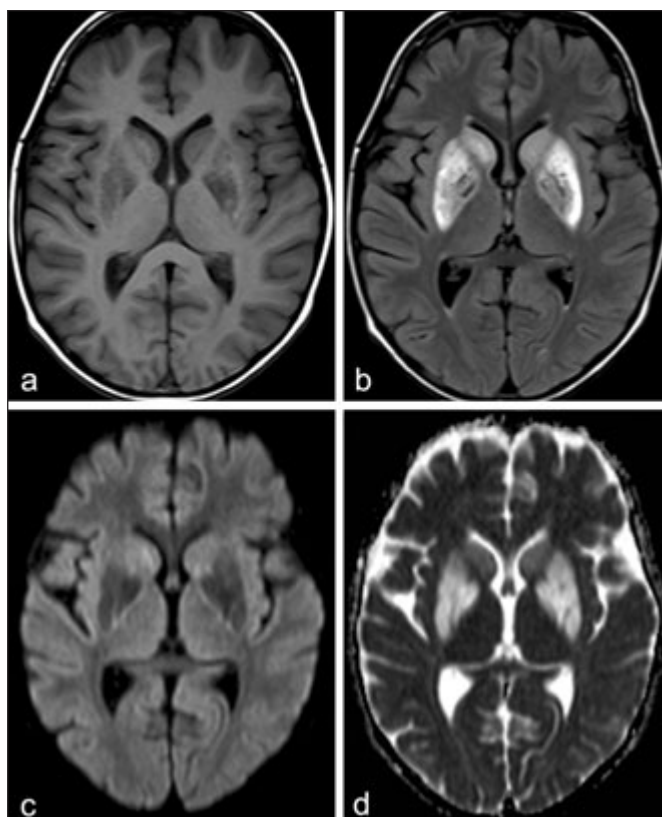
MRI six weeks after initial CT shows persistent signal changes in bilateral basal ganglia. The putamina and globi pallidi are (a) hypointense on T1-MRI (b) predominantly hyperintense on FLAIR images (c) hypointense on DWI (d) and hyperintense on ADC map. The signal changes of the caudate nuclei are much milder, and only appreciated as mild hyperintensity on FLAIR and ADC map.
